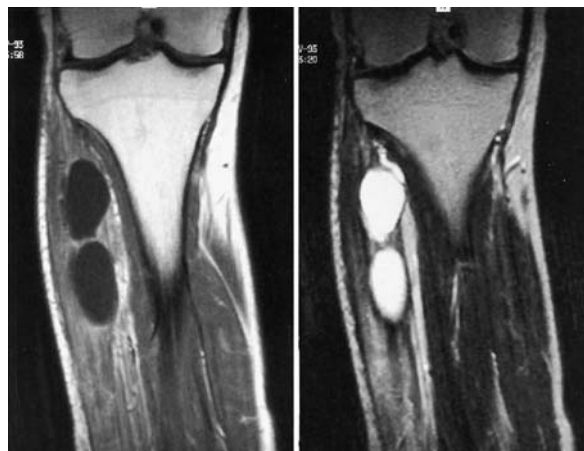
Magnetic resonance images, coronal view, obtained after the first operation. A T_1 -weighted image obtained after injection of gadolinium (left) and a T_2 -weighted image (right) show the recurrent cyst. A narrow extension to the tibiofibular joint is now visible.
